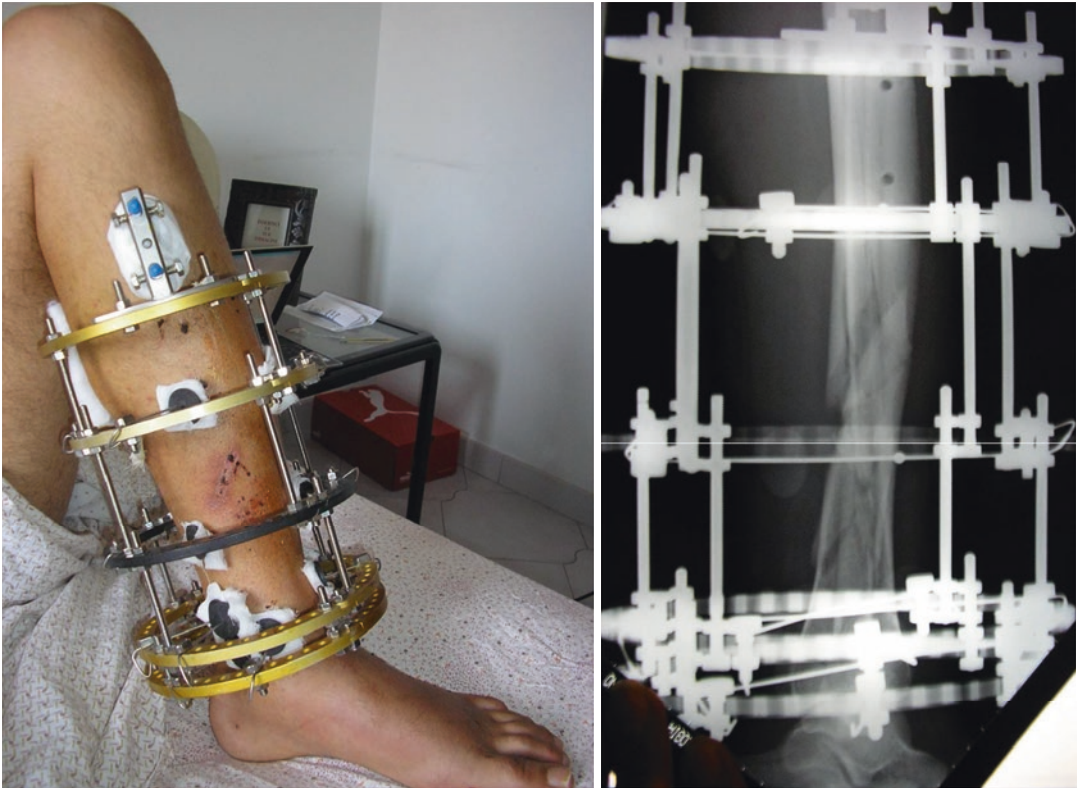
X-ray and photograph of Ilizarov frame in use for a distal tibial fracture (Courtesy of Viapastrengo under Creative Commons Attribution-Share Alike 3.0 license)
